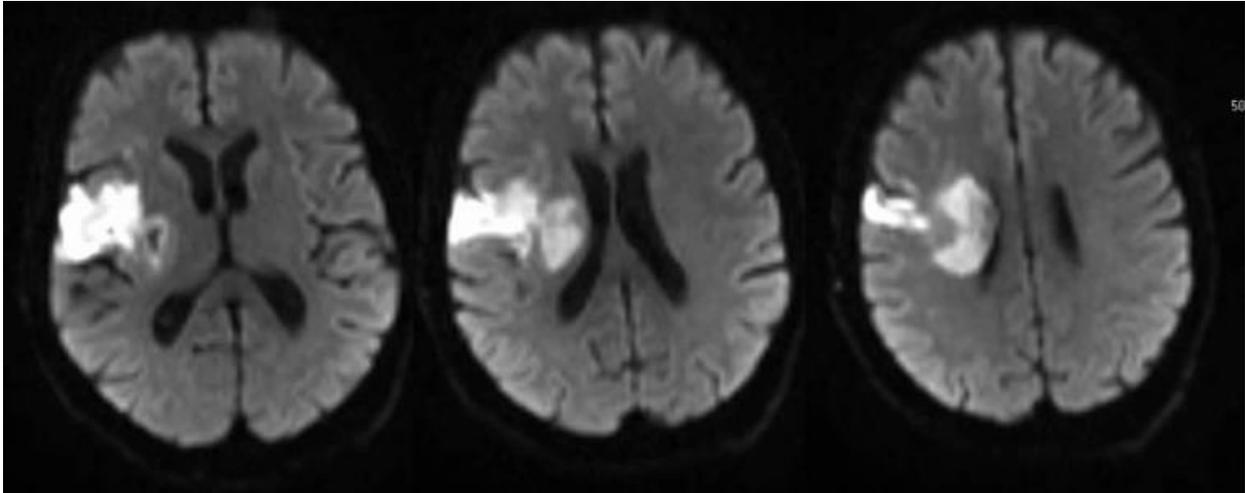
MRI of brain demonstrated stable extension of acute infarction involving multiple zones of the right cerebral hemisphere.
